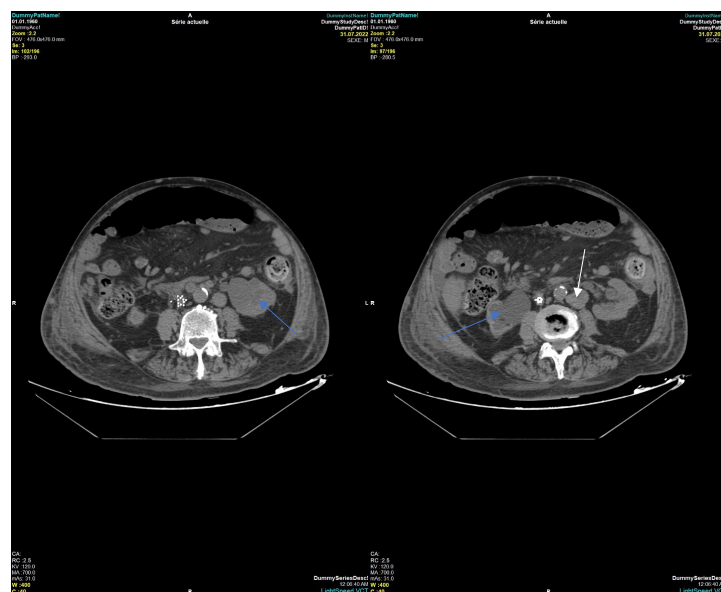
CT scan showing left and right hydronephrosis (blue arrows), and multiple retroperitoneal lymphadenopathies (white arrow).
